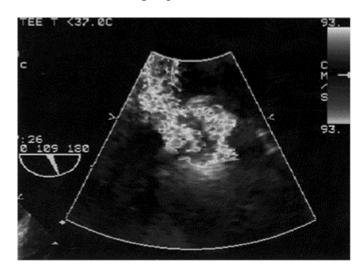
Color Doppler zoom image corresponding to Figure 13.2 shows a large proximal convergence zone, even with high aliasing velocity (93 cm/s), confirming severe regurgitation, as already predicted by the 2-D image.
